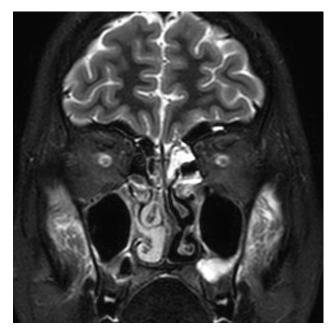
MRI brain and orbits coronal view
